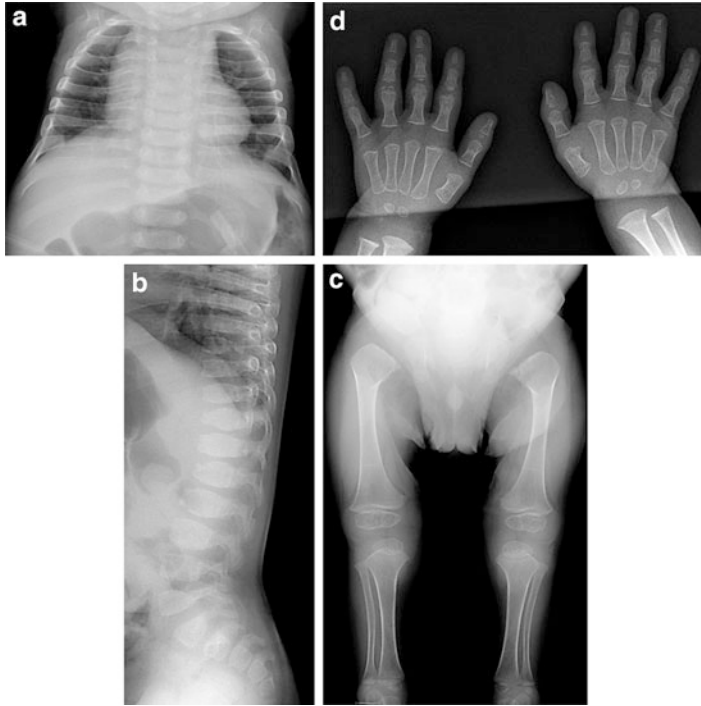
(a–d) A 15-month-old white male with diagnosis of Kniest dysplasia. He is the second child in the family and was born at 38-1/2 weeks by cesarean section. His mother was diagnosed to have polyhydramnios during pregnancy. An antenatal ultrasound demonstrated short limbs and genetic tests confirmed that he positively had Kniest dysplasia. DNA testing showed a gene change within the *COL2A1* gene, consistent with the diagnosis of a Type II collagenopathy. The exact gene change identified was Alal02Val. This change is predicted to cause a small deletion within the amino acid sequence of the protein. He has had a number of medical issues during his early infantile course. He was born with a cleft palate, bilateral
